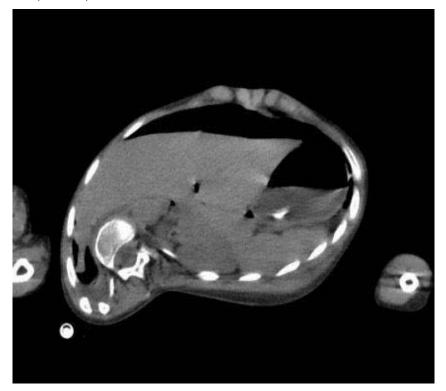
The CT scan of the abdomen, showing marked pneumoperitoneum and the gastrostomy tube in the stomach without evident leak
